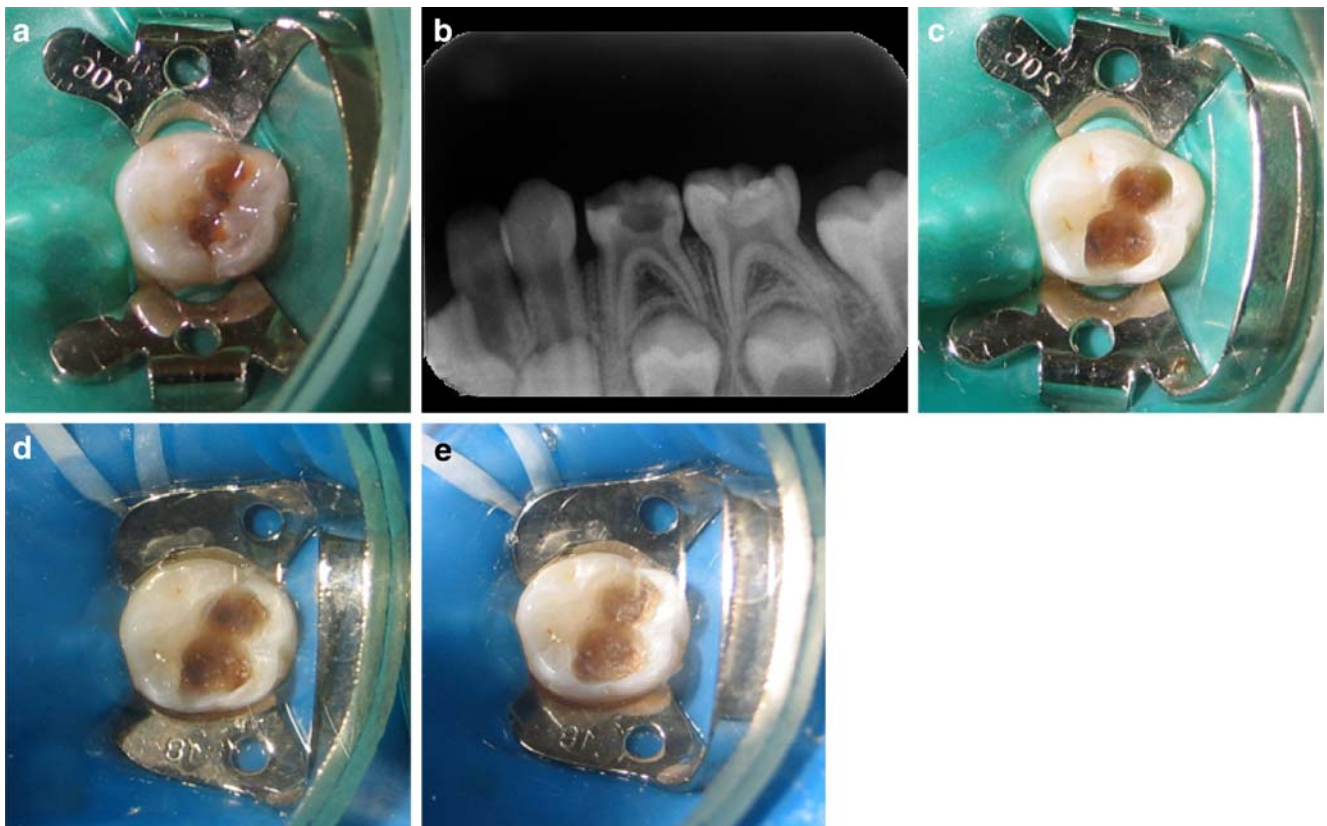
Clinical photographs and radiographs depicting two-visit indirect pulp treatment of mandibular left second deciduous molar: a close-up view of the tooth with a deep carious lesion, b the pretreatment radiograph shows no apical pathosis, but a deep carious lesion, c photograph showing the cavity preparation (incomplete caries
